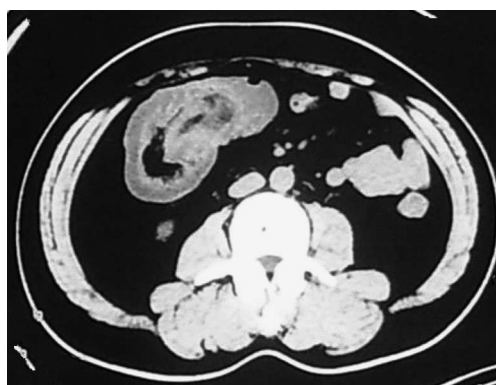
Abdominal computed tomography revealed an intussusception in the right lower quadrant and possible colonic neoplasms.
